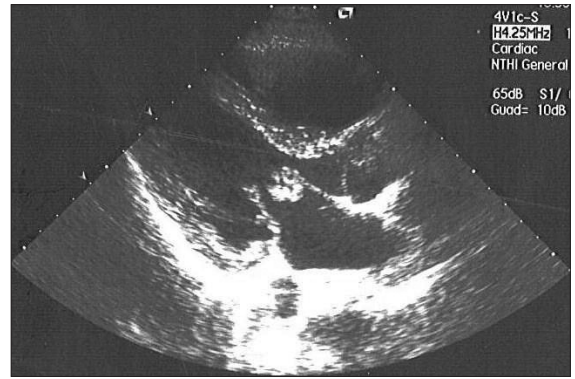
Image along the parasternal axis. The large vegetation, about 1x1 cm, can be seen in the anterior leaflet of the mitral valve, causing outflow obstruction.
